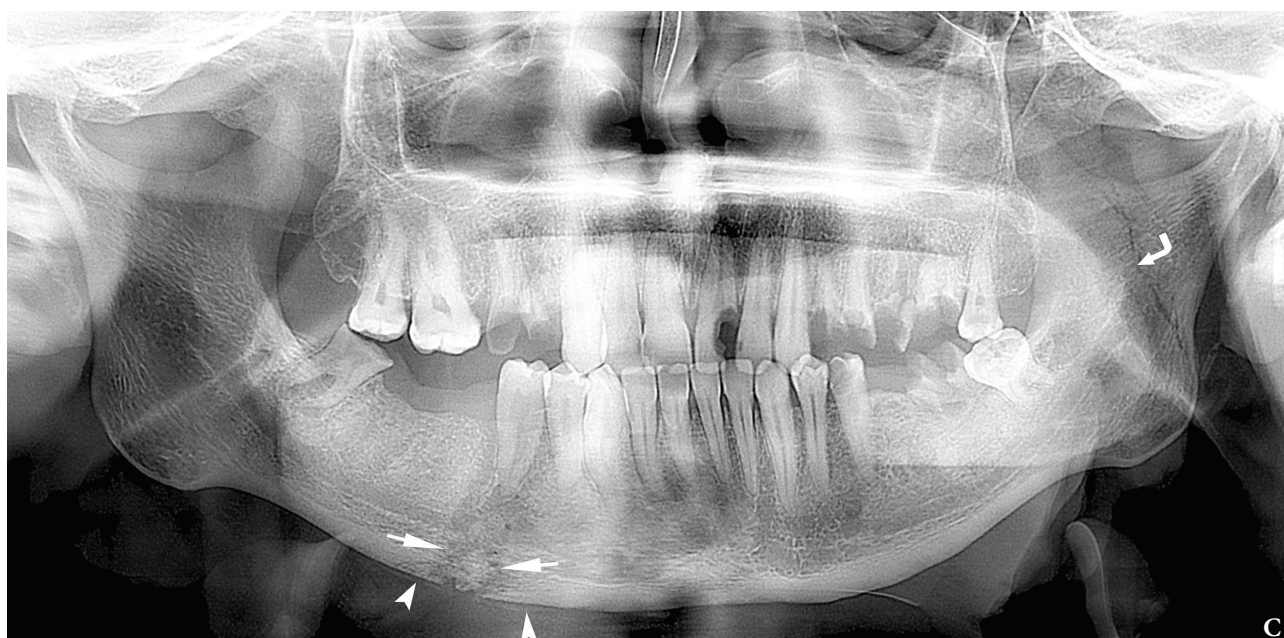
(cont'd). Panoramic x-ray (C) shows irregularity of bony margins in the gap of right body fracture and `doubling` sign (arrows). Left subcondylar fracture – curved arrow. Periosteal reaction at the lower border of the mandible (near the fracture gap) is indicated by arrowheads. (Images of Figure 1 are courtesy of Ievgen I. Fesenko, *Assis Prof*; Kyiv, Ukraine)
